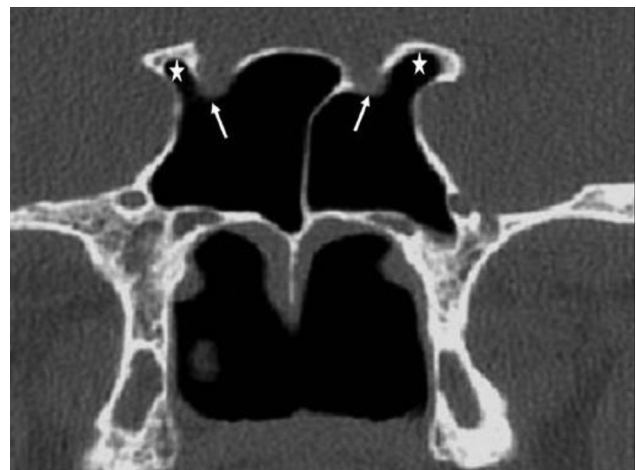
Coronal CT image of a 45-year-old female showing type III Delano's classification of optic.
